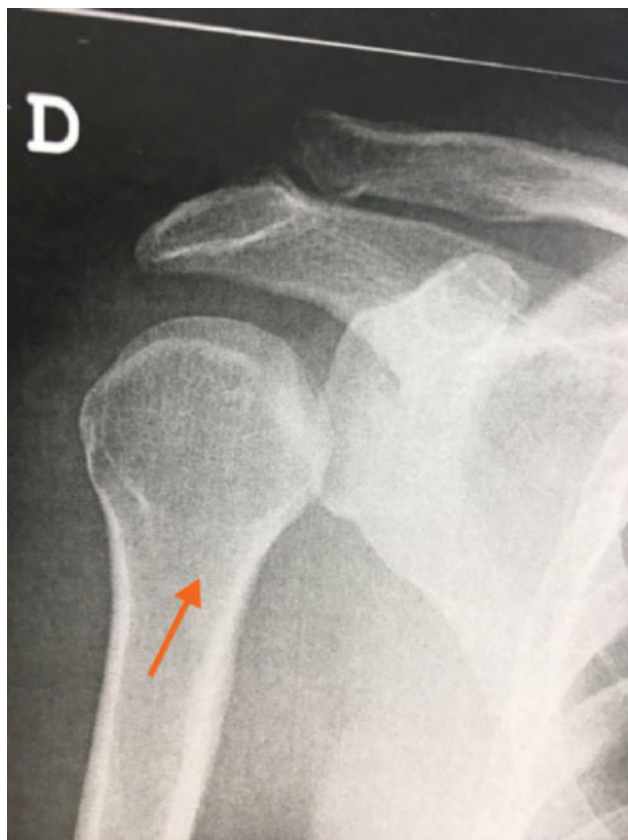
Radiography showing the unreduced posterior glenohumeral dislocation.
